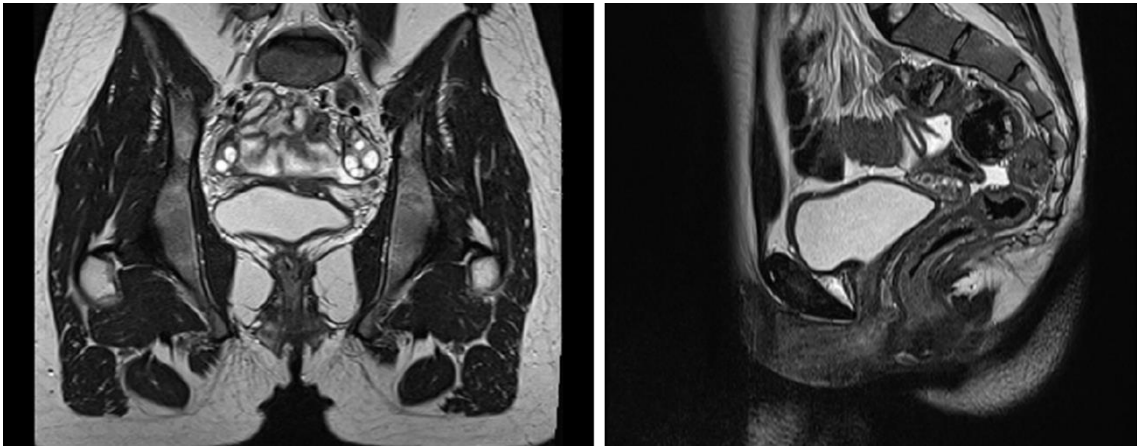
Pelvic Magnetic Resonance (T2-weighted imaging) demonstrating the absence of the uterus. On the left, a coronal cross-section; on the right a sagittal cross-section.
